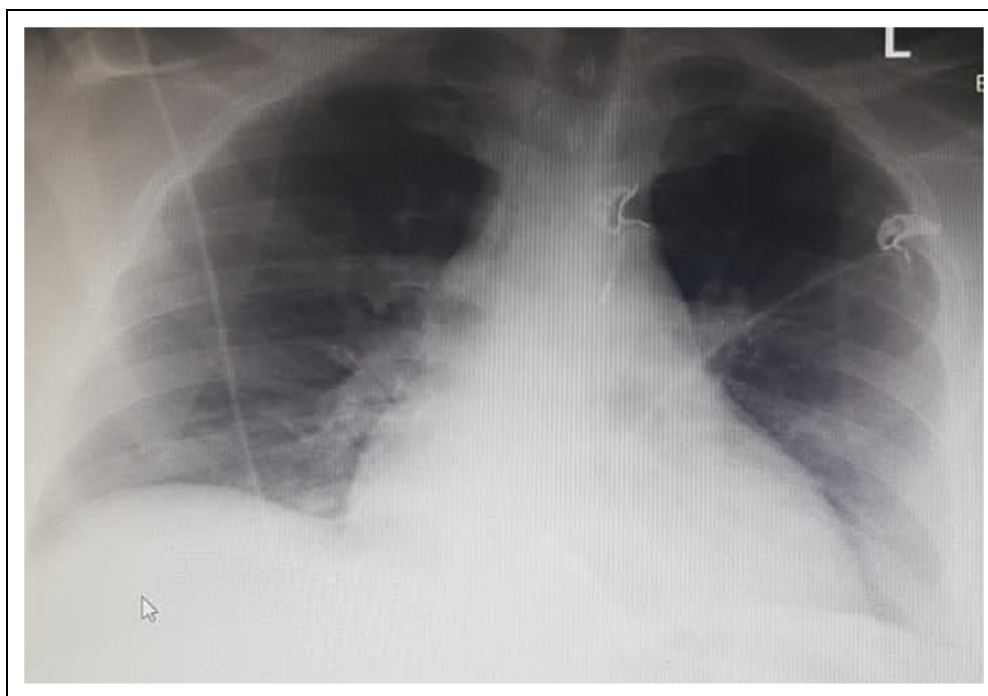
Chest X-ray of Patient 2 showing cardiomegaly.
